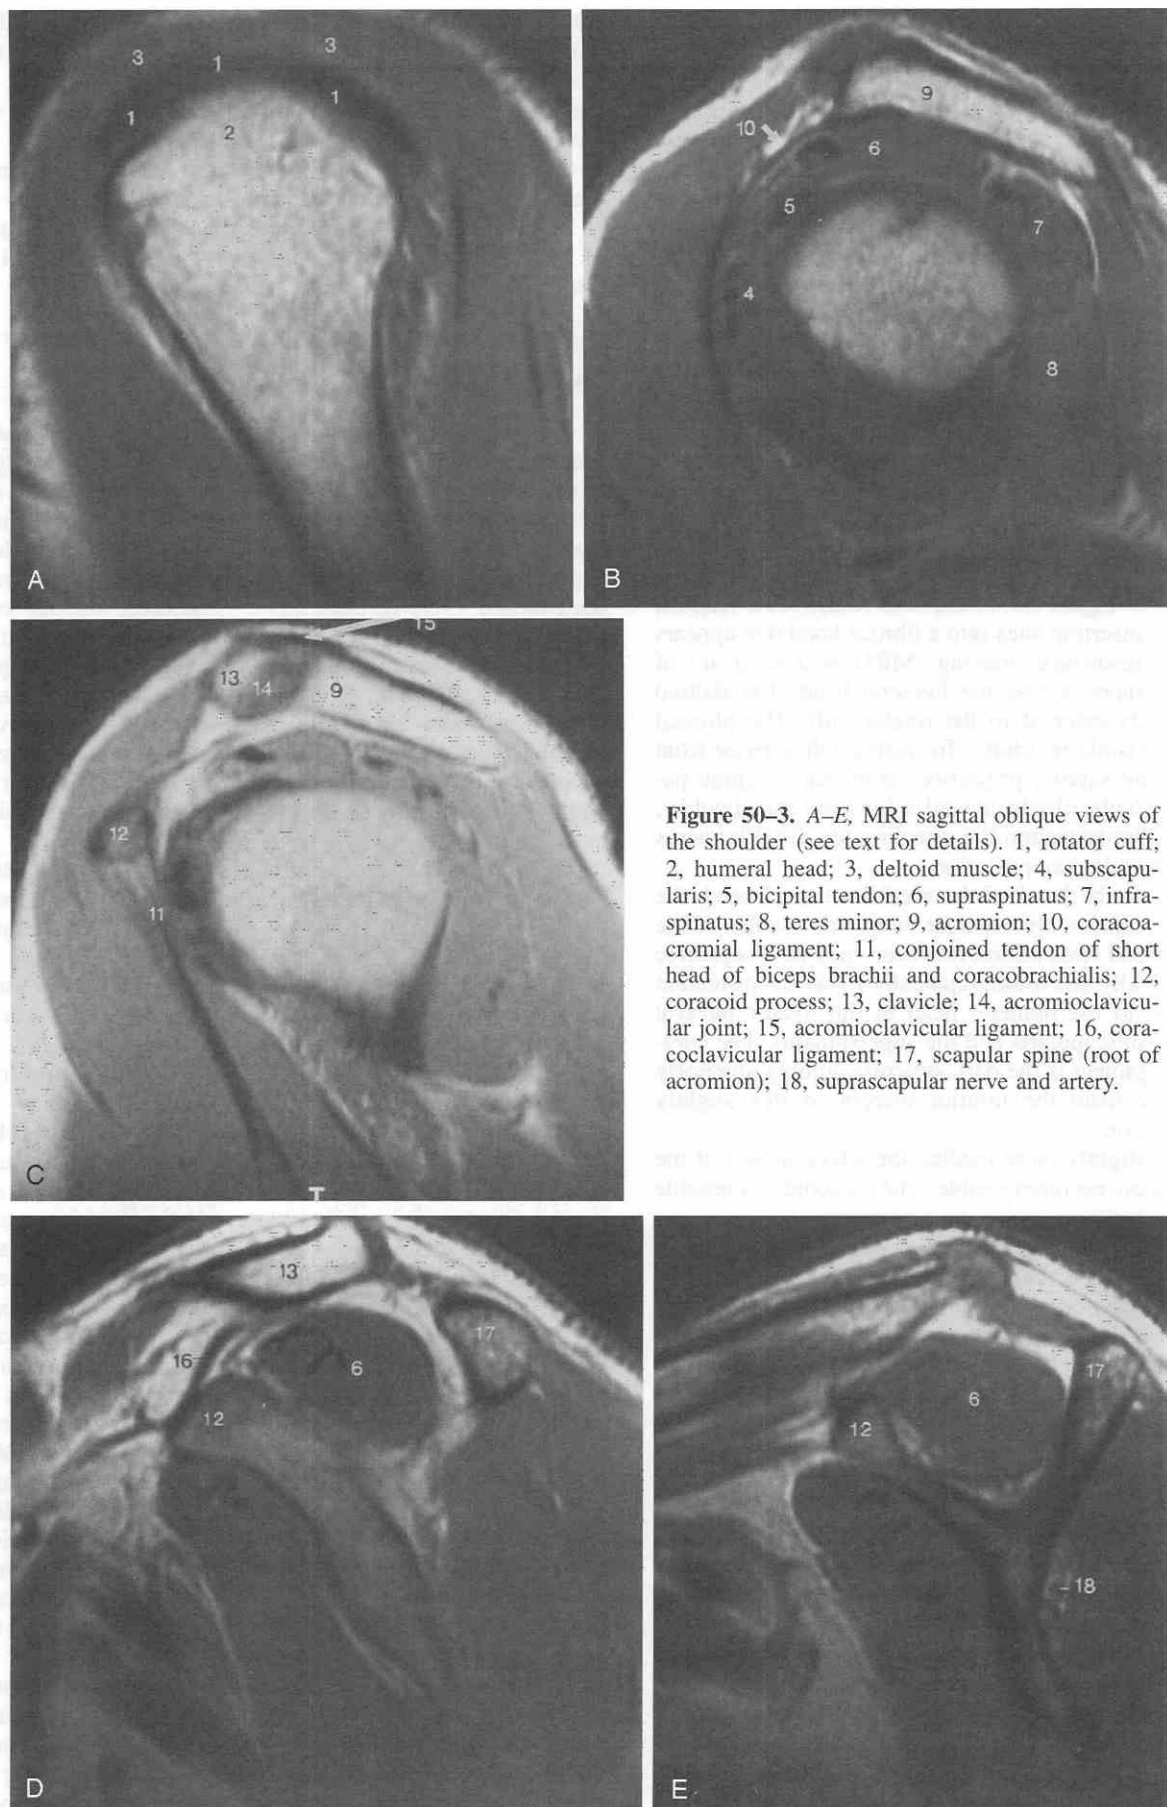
A–E, MRI sagittal oblique views of the shoulder (see text for details). 1, rotator cuff; 2, humeral head; 3, deltoid muscle; 4, subscapularis; 5, bicipital tendon; 6, supraspinatus; 7, infraspinatus; 8, teres minor; 9, acromion; 10, coracoclavicular ligament; 11, conjoint tendon of short head of biceps brachii and coracobrachialis; 12, coracoid process; 13, clavicle; 14, acromioclavicular joint; 15, acromioclavicular ligament; 16, coracoclavicular ligament; 17, scapular spine (root of acromion); 18, suprascapular nerve and artery.
